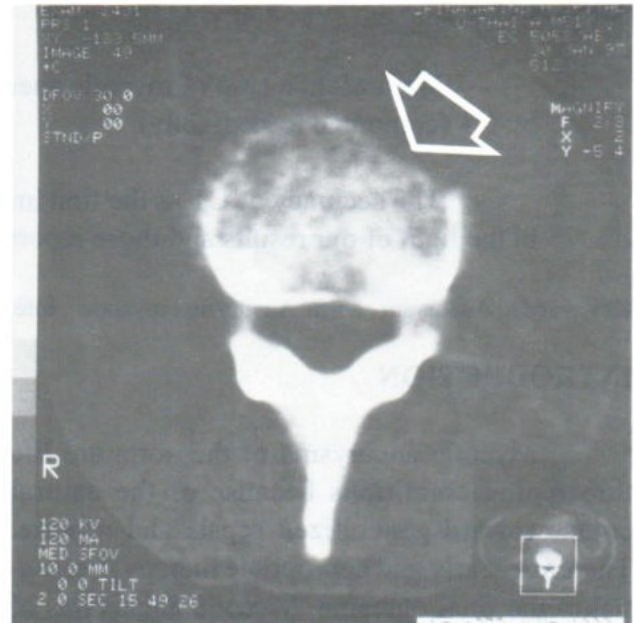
Axial CT., bone algorithm showing osteolytic bone destruction of the adjacent lumbar vertebra (arrow).
